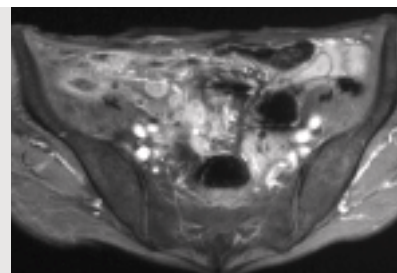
Contrast-enhanced T1-weighted image with fat saturation.
